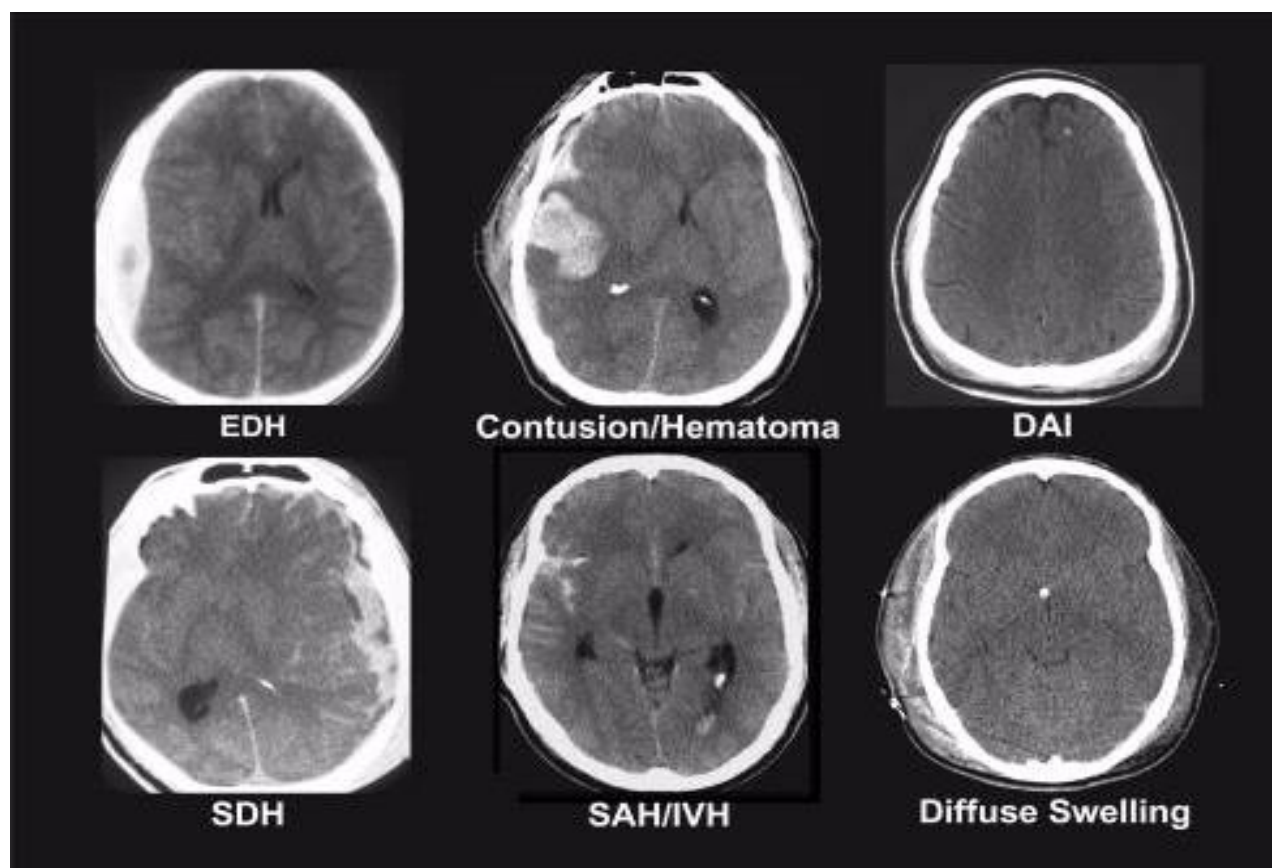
Heterogeneity of severe traumatic brain injury. CT scans represent patients with epidural hematomas (EDH), contusions and parenchymal hematomas (Contusion/Hematoma), diffuse axonal injury (DAI), subdural hematoma (SDH), subarachnoid hemorrhage and intraventricular hemorrhage (SAH/IVH), and diffuse brain swelling (Diffuse Swelling) (30)
